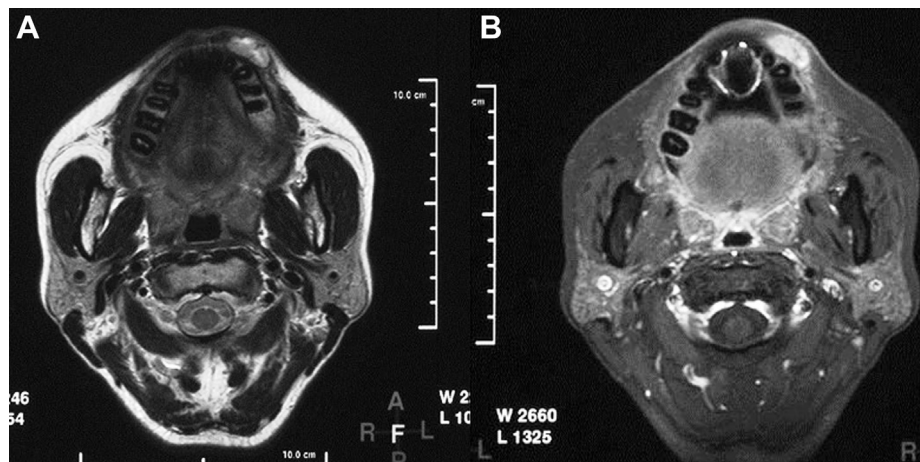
(A) T1-weighted magnetic resonance imaging (MRI), showing that the tumor was heterogeneously enhanced. (B) T2-weighted MRI scan, showing that the tumor had a heterogeneous, predominantly increased signal and internal septa of low signal isointensity.
